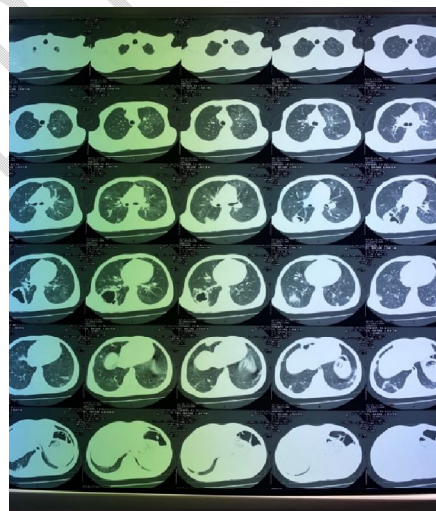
CT Thoracic angiogram showing right lobar pulmonary embolism with foci of infarction
